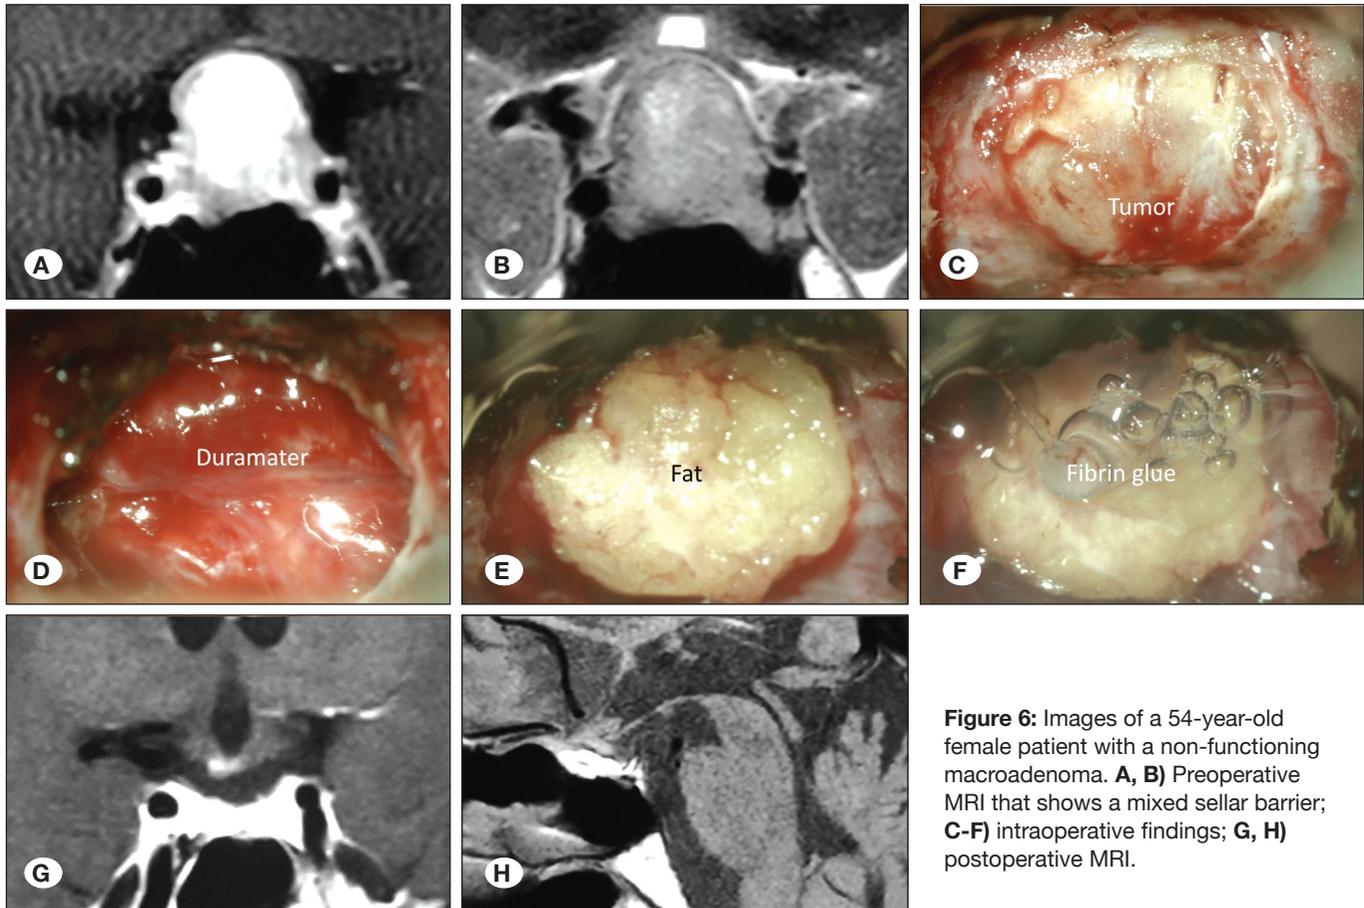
Images of a 54-year-old female patient with a non-functioning macroadenoma. A, B) Preoperative MRI that shows a mixed sellar barrier; C-F) intraoperative findings; G, H) postoperative MRI.
